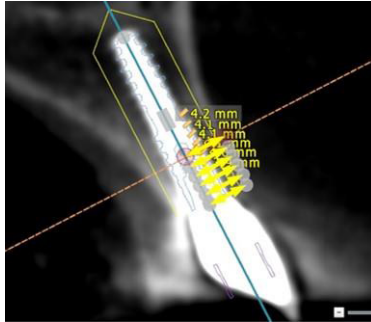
Planning implant superimposed over the implant in the CBCT image according to the exact coordinates obtained.
